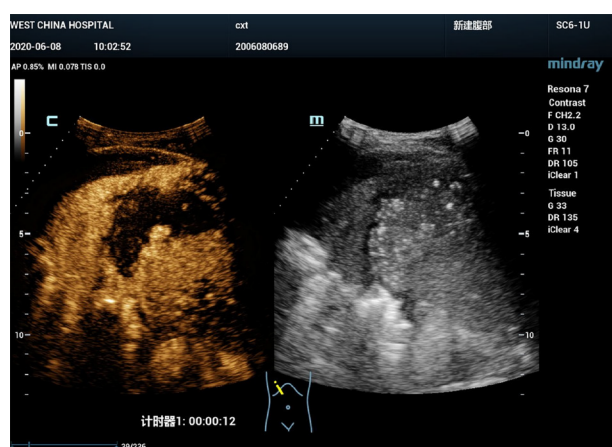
First-time intravenous contrast-enhanced ultrasound showed that the right subphrenic mass (6.0 cm × 3.0 cm) presented a large-scale non-enhancement area with slightly enhanced septa inside.
